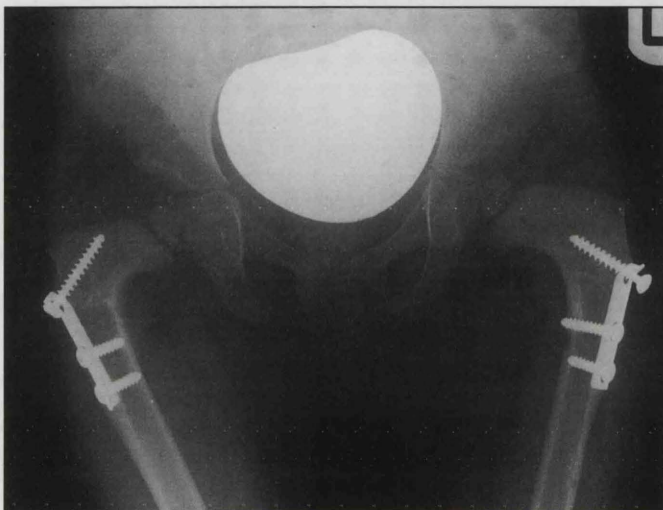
Radiograph following bilateral open reductions and femoral osteotomies
